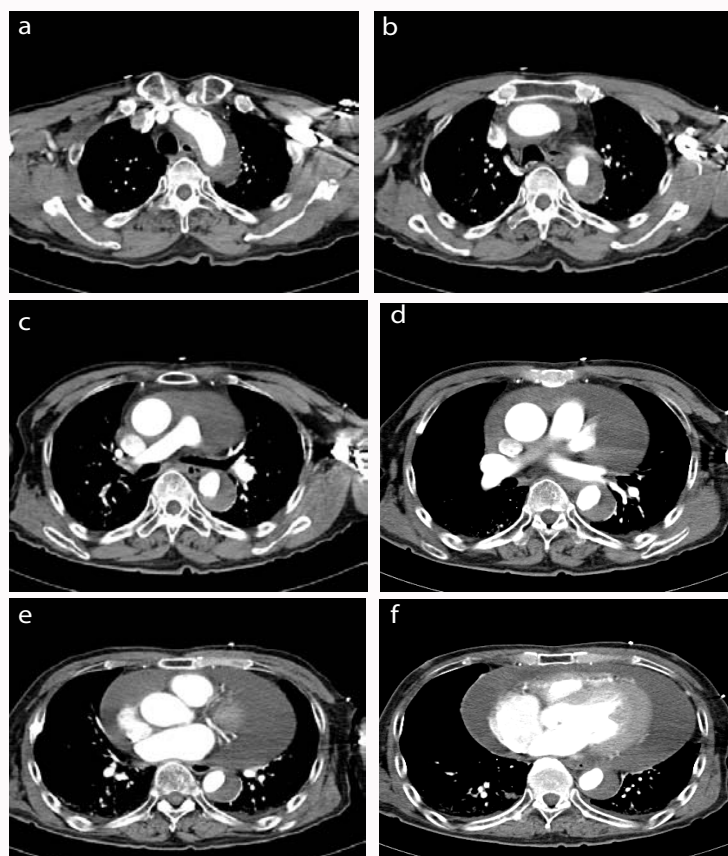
Preoperative chest computed tomographic scan (a-f).
